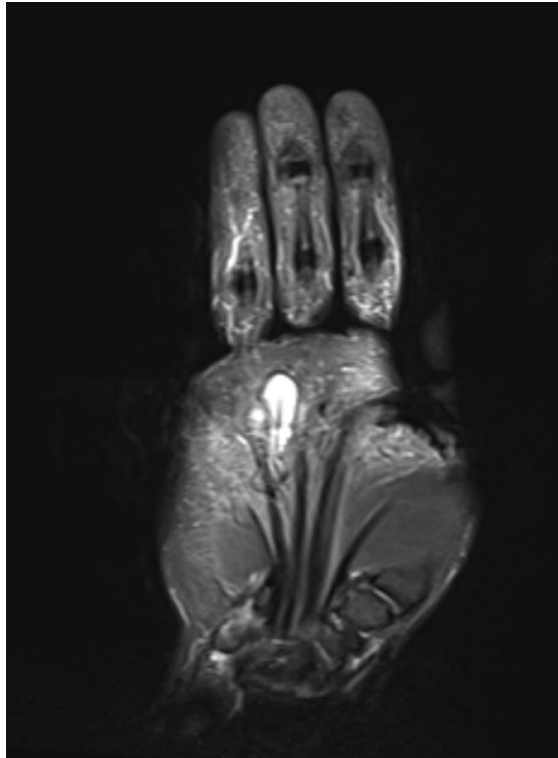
Coronal MR image of digital artery aneurysm
